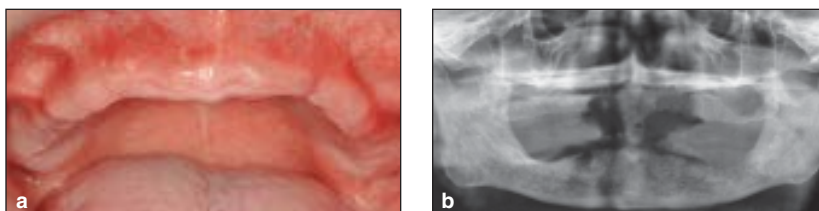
Edentulous maxilla with four implant-supported TC overdentures. (a and b) The standard oral and radiographic examinations, (c and d) examination of the implant, (e and f) overdenture fabrication, and (g and h) implant-supported removable prosthetic rehabilitation with TCs.
